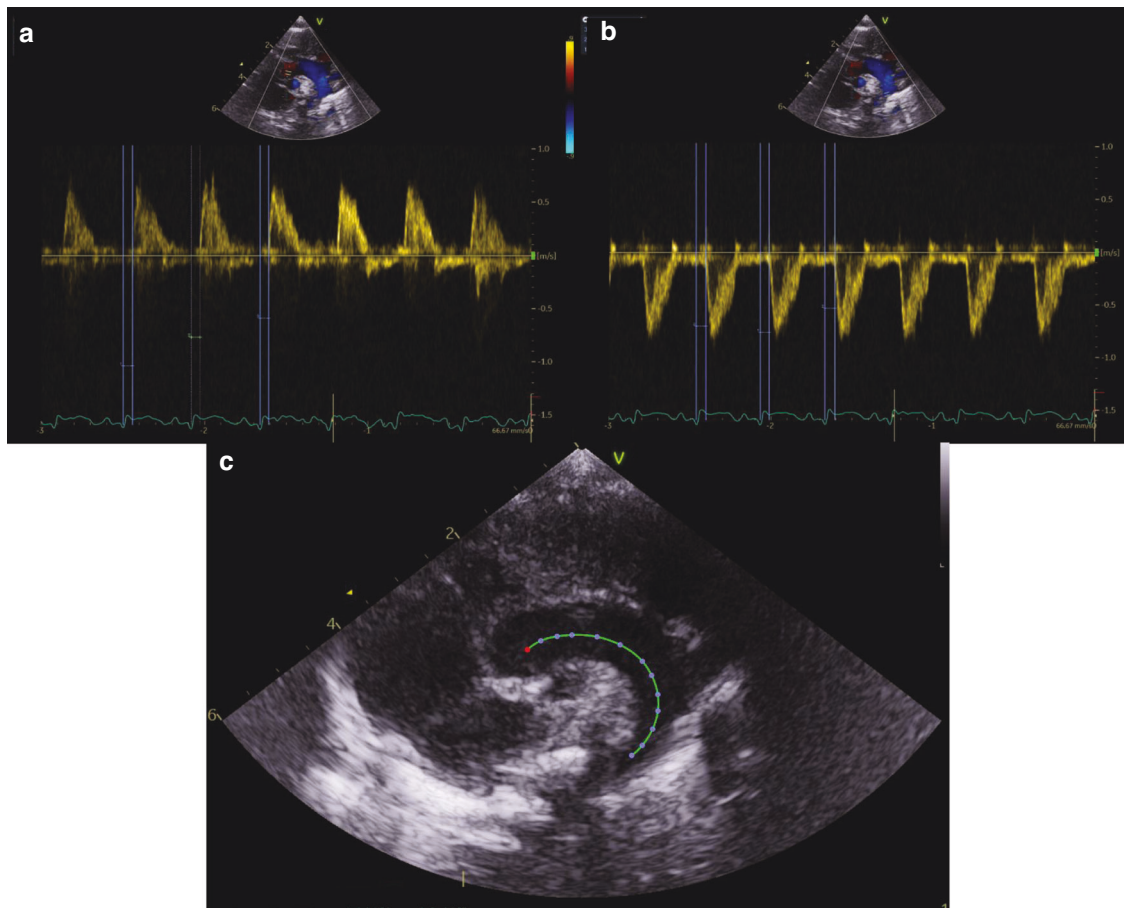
Measurement of the aPWV based on two separate Doppler recordings of one single two-dimensional cross-section of the aorta. a Pulsed Doppler recording at the level of the AV with three measurements of time until flow, b pulsed Doppler recording at the descending aorta at the level of the diaphragm (or as distal as possible if unattainable) with three measurements of time until flow, c length of the aorta from the location of pulsed Doppler recording A to pulsed Doppler recording B. As time intervals were studied rather than the height of the signal, central placement was not relevant.
